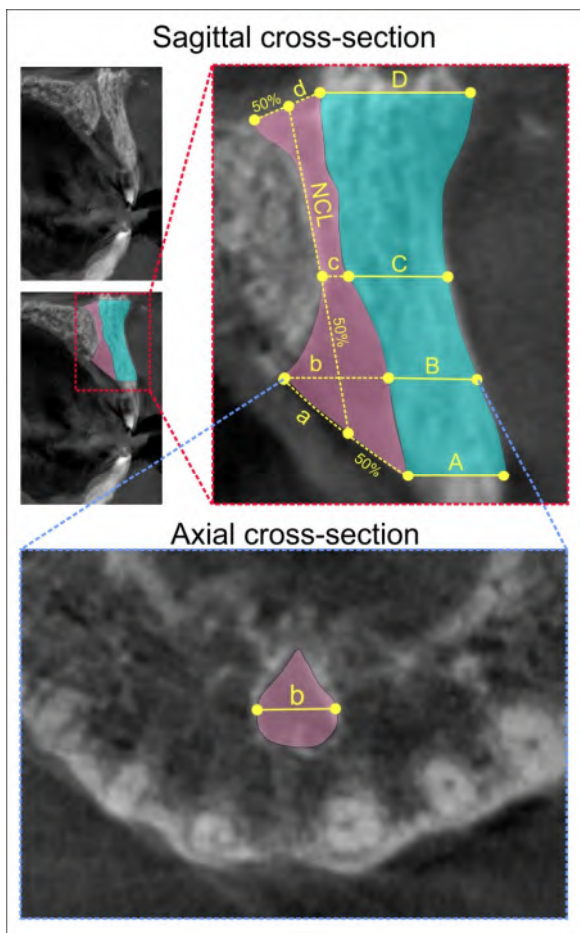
CBCT image analysis strategy.
